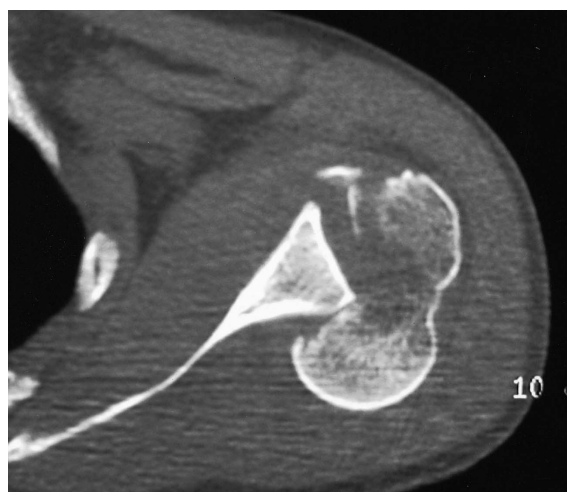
CT examination of the left shoulder shows posterior locked fracture-dislocation.
